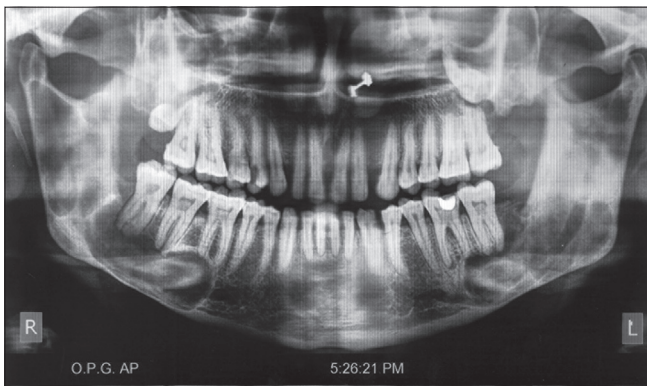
Patient 2: Follow up radiograph after 2 years showing bone healing
